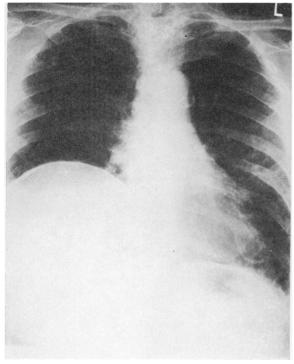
(top left). Postero-anterior x-ray of chest, showing the large round calcified cyst in the right lobe of the liver.
